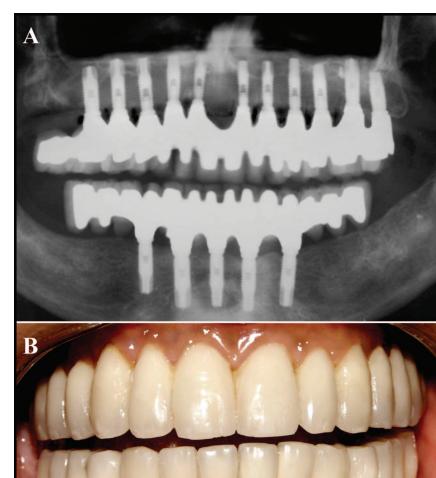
The final panoramic x-ray after permanent prosthesis connection (A). Four years after the end of treatment, esthetic result is stable (B).
